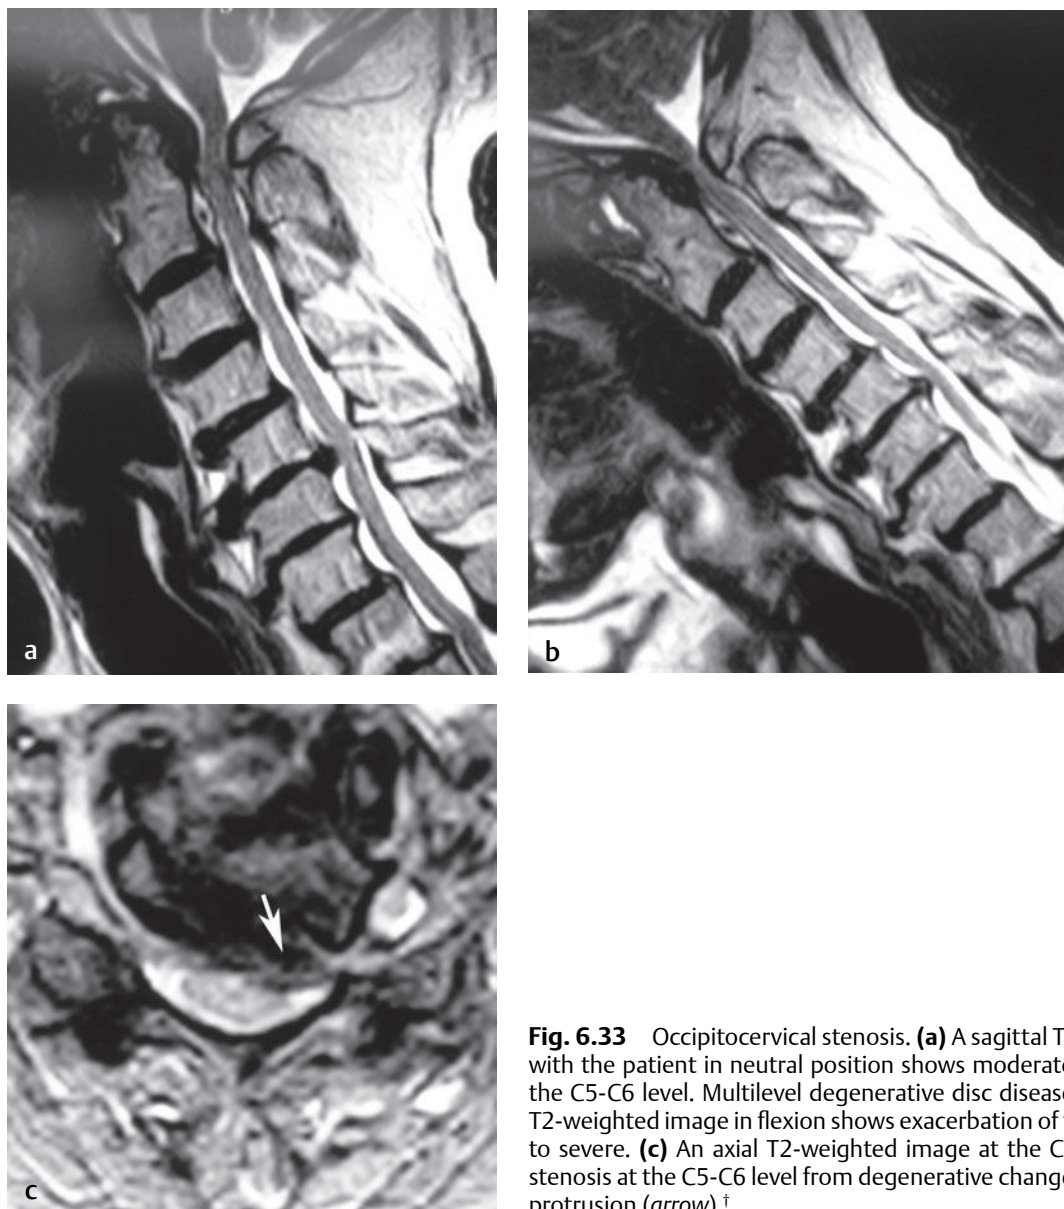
Occipitocervical stenosis. (a) A sagittal T2-weighted image obtained with the patient in neutral position shows moderate stenosis at the OCJ and at the C5-C6 level. Multilevel degenerative disc disease is also seen. (b) A sagittal T2-weighted image in flexion shows exacerbation of the occipitocervical stenosis to severe. (c) An axial T2-weighted image at the C5-C6 level shows moderate stenosis at the C5-C6 level from degenerative changes and a left paracentral disc protrusion (arrow).[†]
